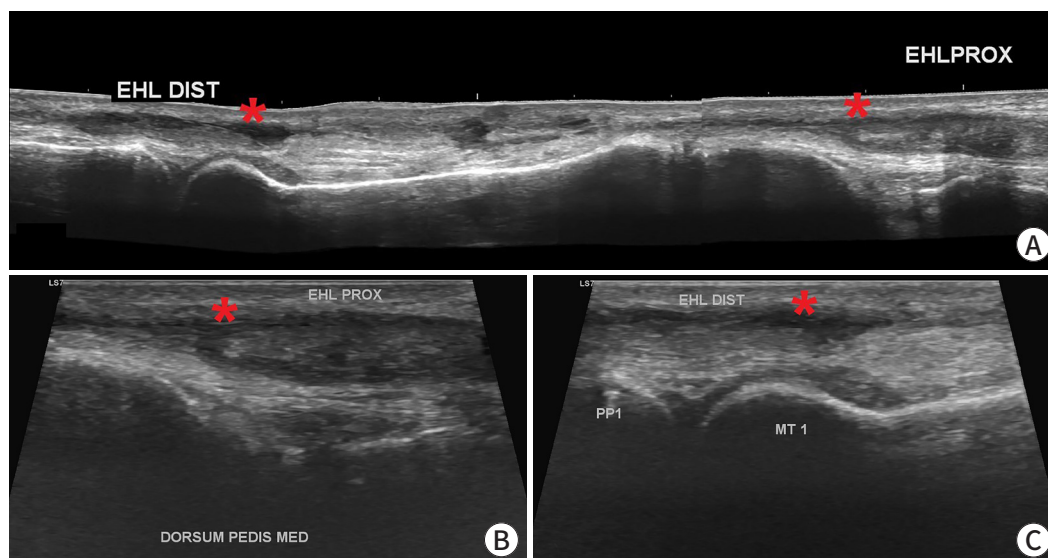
Preoperative ultrasonography was performed to evaluate the integrity of the extensor hallucis longus (EHL). (A) Longitudinal ultrasound imaging of the dorsal aspect of the left ankle showed complete rupture of the EHL tendon with a gap between the stumps (asterisk). (B) The proximal stump (asterisk) of the torn EHL tendon was at the medial cuneiform level. (C) The distal stump (asterisk) of the torn EHL tendon was isolated at the metatarsal level. EHL DIST, distal EHL; EHL PROX, proximal EHL; DORSUM PEDIS MED, dorsum pedis medial; PP1, proximal phalanx 1; MT1, metatarsal 1.
